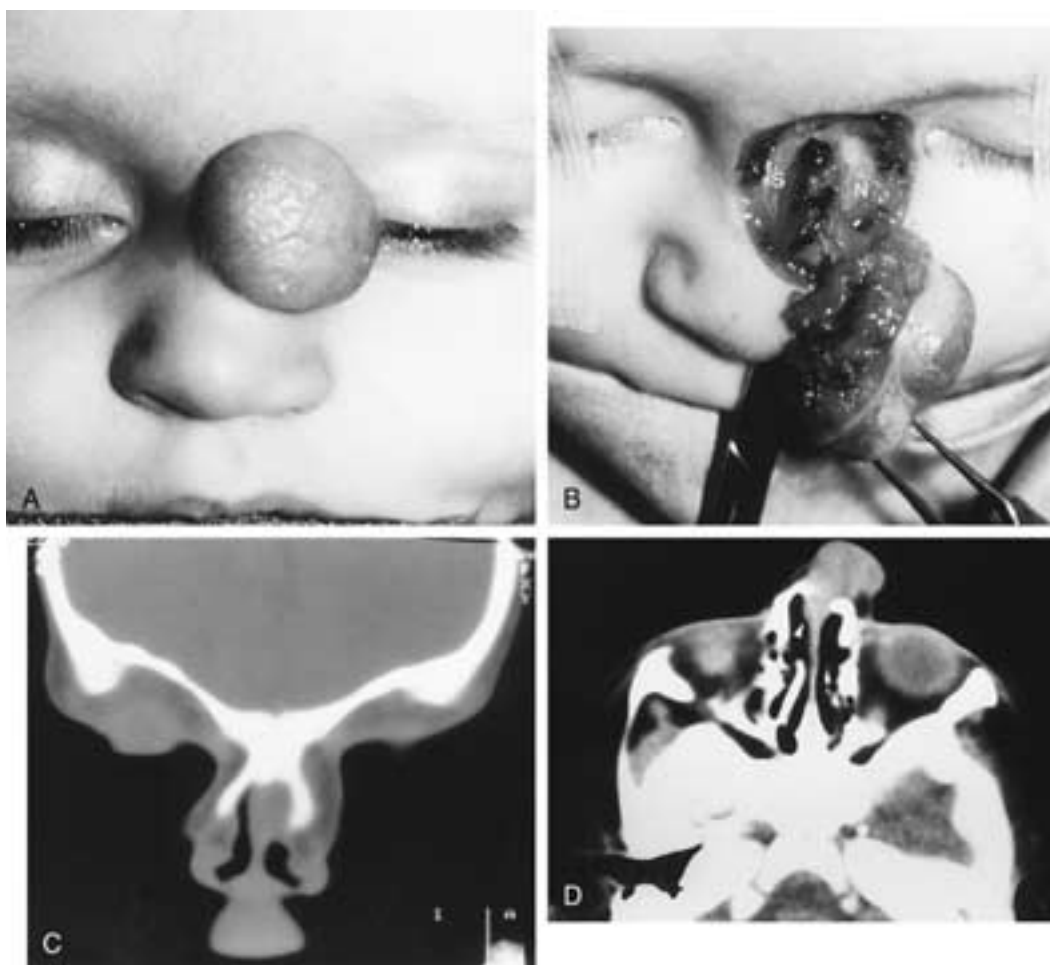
Mixed extranasal-intranasal glioma in a 6-month-old boy. A, Facies. The globular mass overlies the dorsum of the nose on the left. B, At surgery the lesion was found to have extended through the left nasal bones, bowed the septum (*S*) rightward, and bowed the residual left nasal bones (*N*) leftward. It was attached by a pedicle to the foramen cecum. C and D, Coronal and axial CT scans show that the mass extends through the resultant defect into the thickened nasal septum (*white arrowhead* in D). The crista galli and brain were normal. (Courtesy of Dr. Sharon Byrd, Chicago.)
